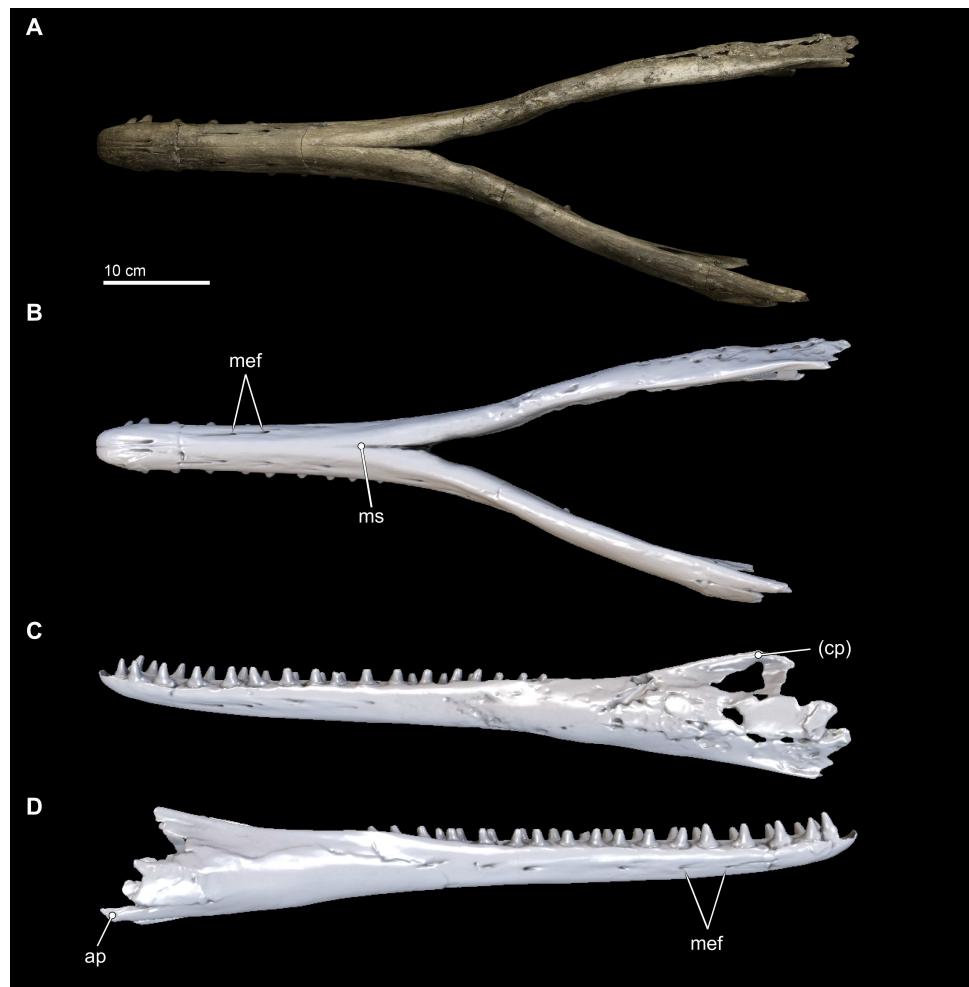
Mandibles in ventral and lateral views. Ventral views of the mandibles of *Isthminia panamensis* (USNM 546125) from (A) photographs and (B) orthogonal digital three-dimensional polygon model prepared from CT data, with lighting and color modifications using the Smithsonian X 3D browser. (C) Left lateral and (D) right lateral views of the mandibles of *Isthminia panamensis* (USNM 546125) from orthogonal digital three-dimensional polygon model prepared from CT data. See <http://3d.si.edu/explorer?s=cavfn3> (ventral view), <http://3d.si.edu/explorer?s=dGTRVj> (left lateral), and <http://3d.si.edu/explorer?s=cLO5aZ> (right lateral) to measure, modify, or download this model. Parentheses denote missing structure(s).
